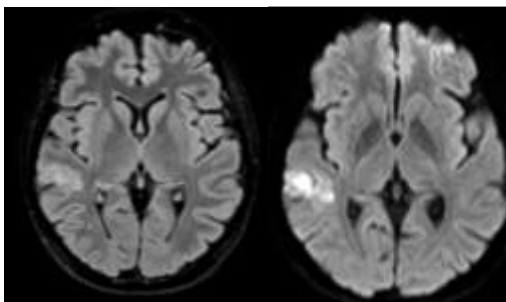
Brain MRI (FLAIR/DWI sequences) shows an area of hyperintense signal with mild diffusion restriction in the right temporal region.
